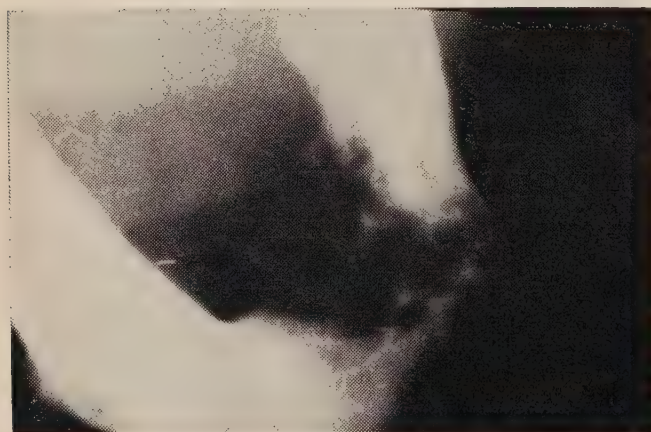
Radiographie latérale droite (2 mois, post-opératoire).
